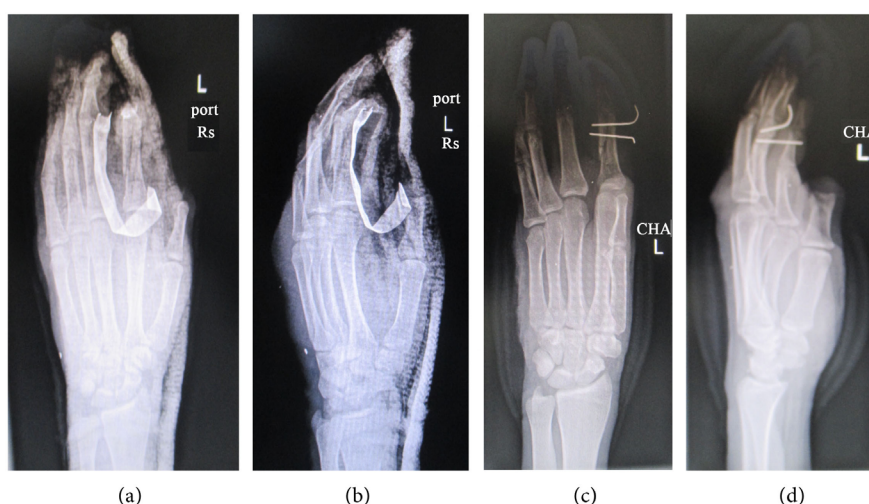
X-rays of the patient. (a) & (b) Preoperative X-rays anteroposterior and oblique views; (c) & (d) Postoperative X-rays anteroposterior and oblique views.
